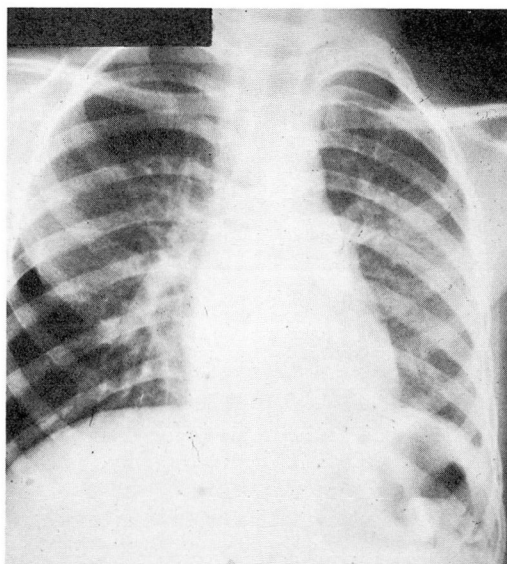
Chest roentgenogram taken on the ninth postoperative day, before the patient was discharged from the hospital.
